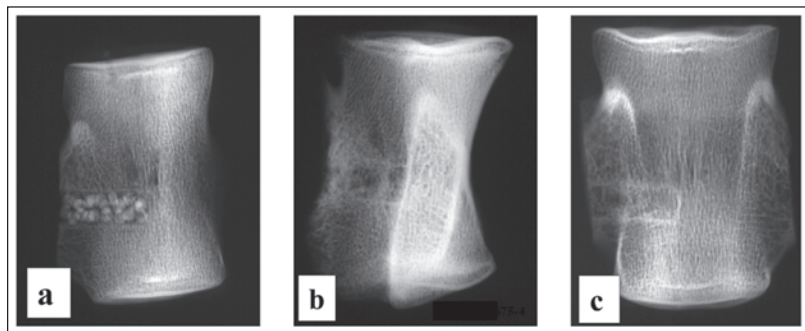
Postoperative radiographs of vertebral defects filled with coral granules. a) Immediate post-implantation b) after 2 months c) after 4 months.
